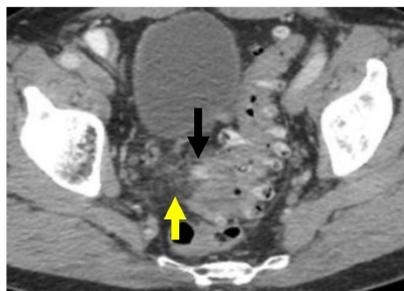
Acute uncomplicated sigmoid diverticulitis. Axial CT image through the pelvis with oral and IV contrast. There is extensive sigmoid diverticulosis. There is inflammatory stranding within the fat (yellow arrow), which is centered on a sigmoid diverticulum (black arrow). There is no evidence for free air or adjacent fluid collection.
